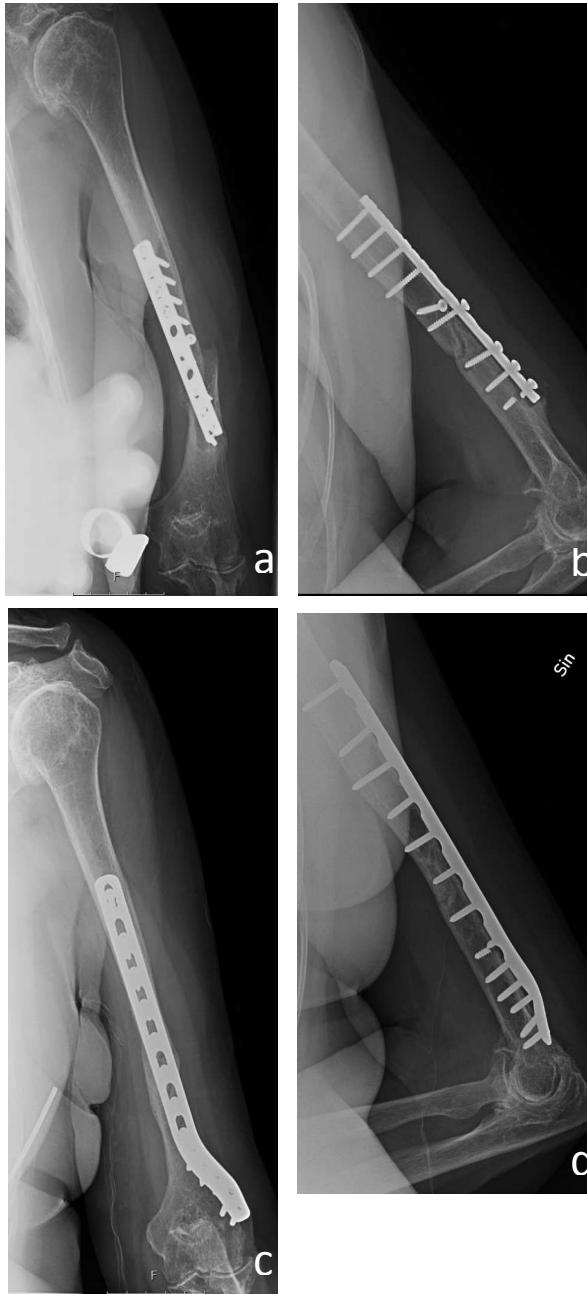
a-d: Atrophic nonunion following plate osteosynthesis in a patient with rheumatoid disease. a & b) Anteroposterior and lateral radiographs showing displaced fracture and broken screw. c & d) Anteroposterior and lateral radiographs showing healed fracture after revision surgery with compression plating and autologous bone grafting.
